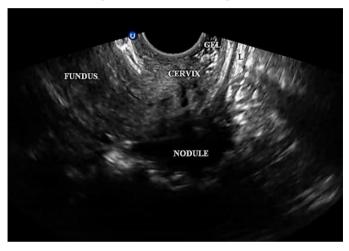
A transvaginal ultrasound image (sagittal plane) showing a deep infiltrating endometriotic nodule involving the anterior rectum. The "sliding sign" was negative at the retro-cervical region (due to adhesions between the anterior rectal nodule and posterior cervix), indicating a complete pouch of Douglas obliteration *L: Lumen of the rectum*
